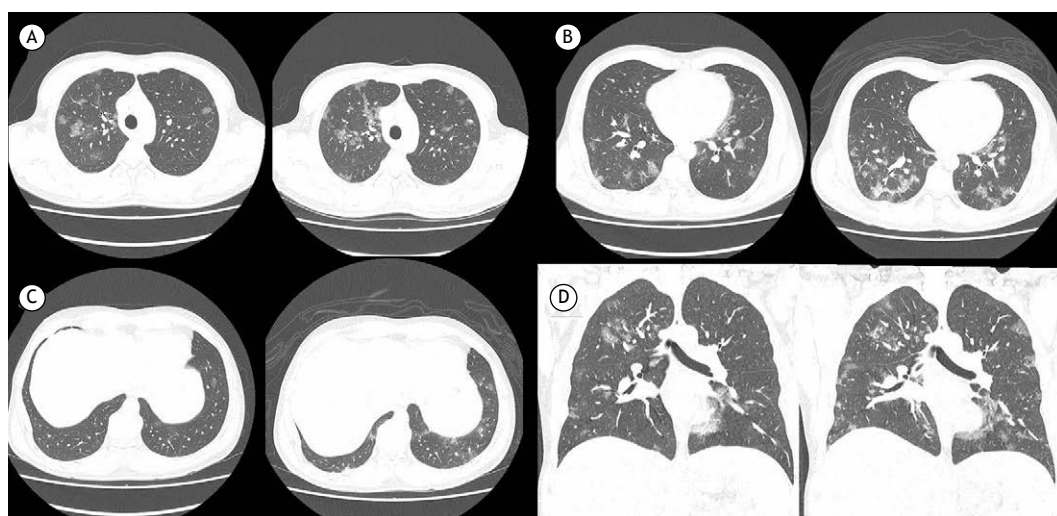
Axial images (in A to C) and coronal reconstructions (in D) of chest CT scans of a 44-year-old man with clinical findings suggestive of COVID-19 (fever, sore throat, and frequent dry cough), demonstrating the most commonly described pattern: numerous bilateral multifocal ground-glass opacities, associated with fine reticulation and interlobular septal thickening (crazy-paving pattern), involving various lung lobes and being predominantly peripheral in distribution in the parenchyma and a little more extensive in the posterior regions of the lower lobes. The patient had a positive RT-PCR result for COVID-19 on the day he underwent the first CT scan (images on the left in each pair) and was hospitalized. A second CT scan, which was performed three days later (images on the right in each pair) because he continued to have fever spikes and dry cough, demonstrated an increase in the number and extent of pulmonary opacities.
